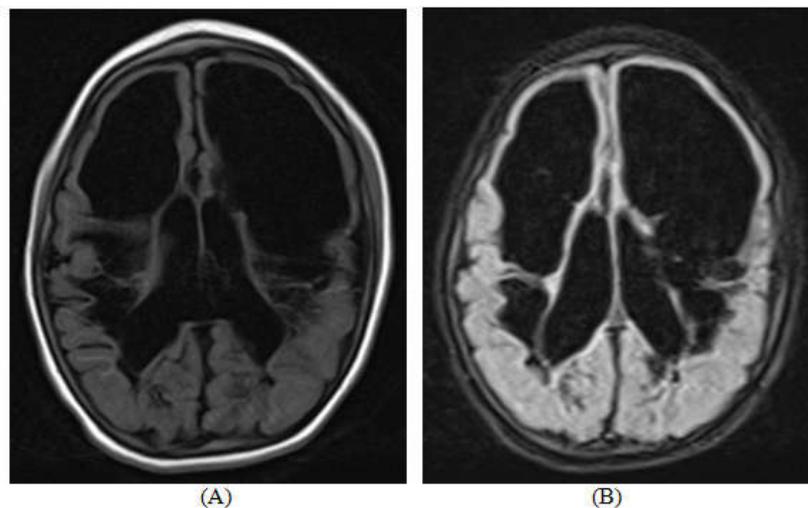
Multicystic encephalopathy (A) T1 FLAIR, axial (B) T2 FLAIR, axial
